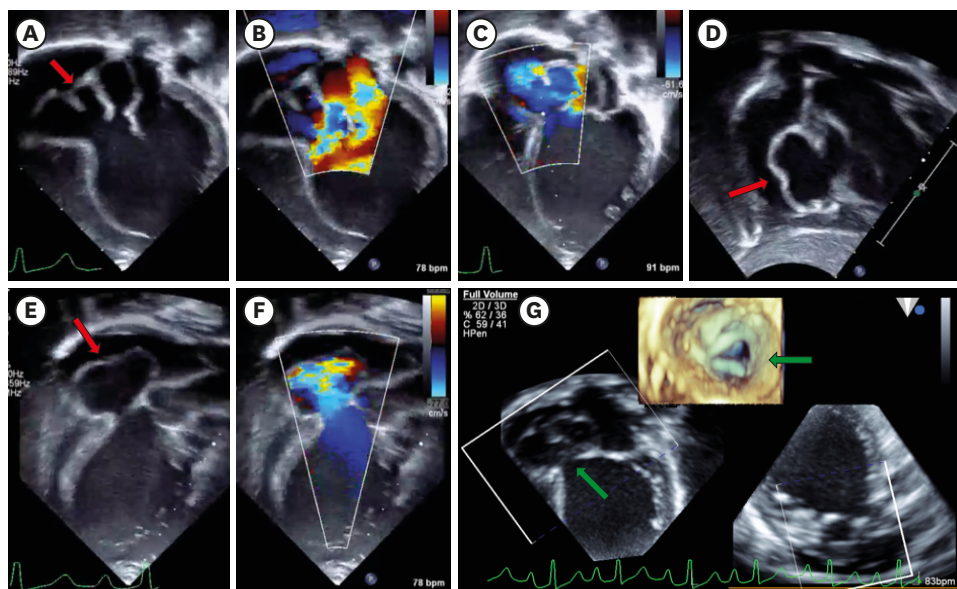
Echocardiogram showing multiple sub valvular aneurysms in (A) apical 4 chamber view with (B, C) to and fro flow and in the subcostal view (D). (E, F) The oblique view showing the large aneurysm close to aortic annulus (red arrow). (G) Three dimensional I crop view showing opening of the larger aneurysm from left ventricle side (green arrow).
